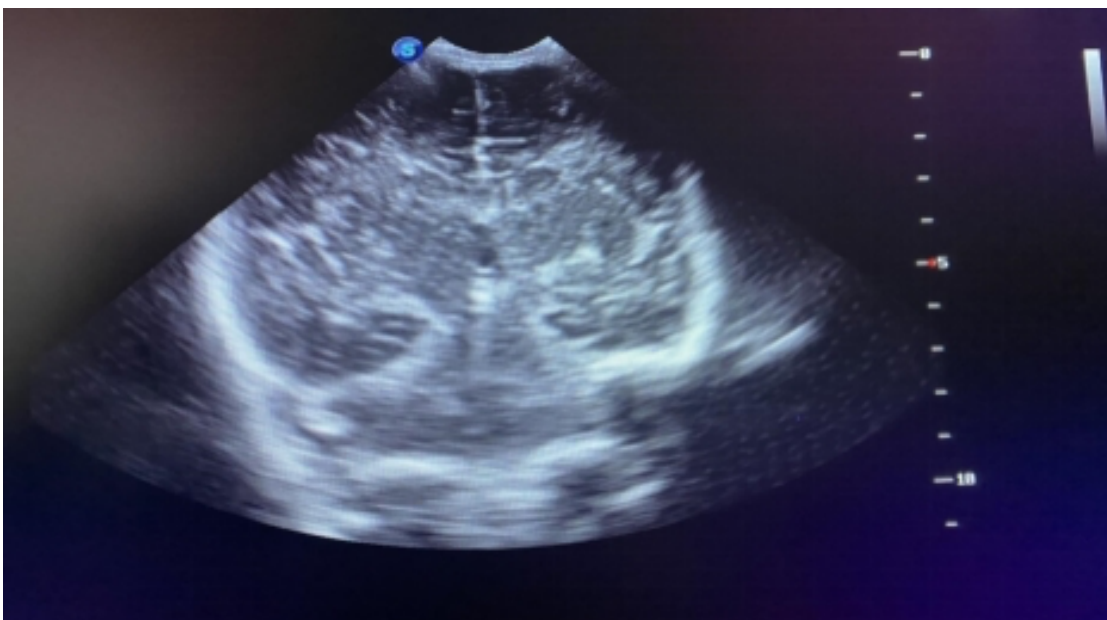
Neurosonogram of newborn M, 3 days old
